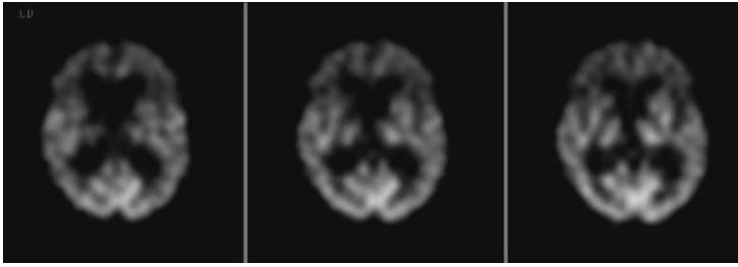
FDG-PET scan of a patient with Pick's disease demonstrating moderately decreased metabolism in the frontal lobes including the anterior cingulate gyrus. The temporoparietal, occipital, and subcortical areas have relatively preserved metabolism.
